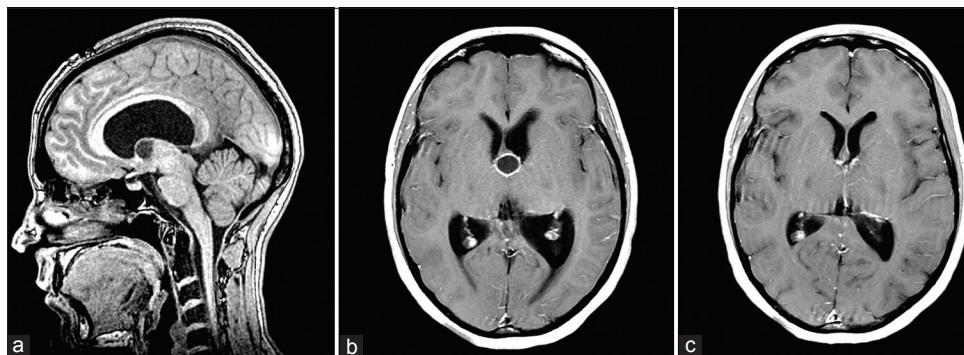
Preoperative T1-weighted magnetic resonance imaging (MRI) in sagittal view (a) and axial view post-Gadolinium (b) showing the third ventricular colloid cyst. Postoperative T1-weighted MRI in axial view post-Gadolinium (c) showing complete resection of the colloid cyst.
